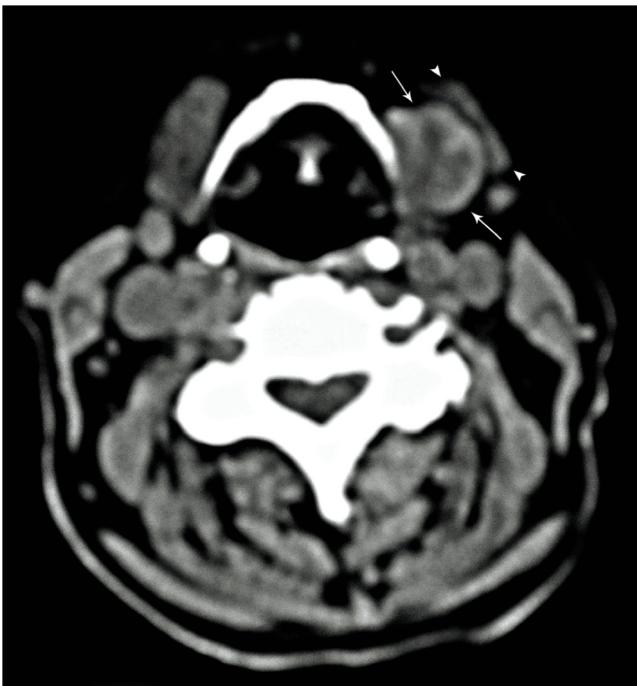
Case 1: CT showed an inhomogeneous, possibly malignant, soft tissue mass (arrows) on the inside of the left submandibular gland (arrowheads), probably due to an enlarged lymph node.
